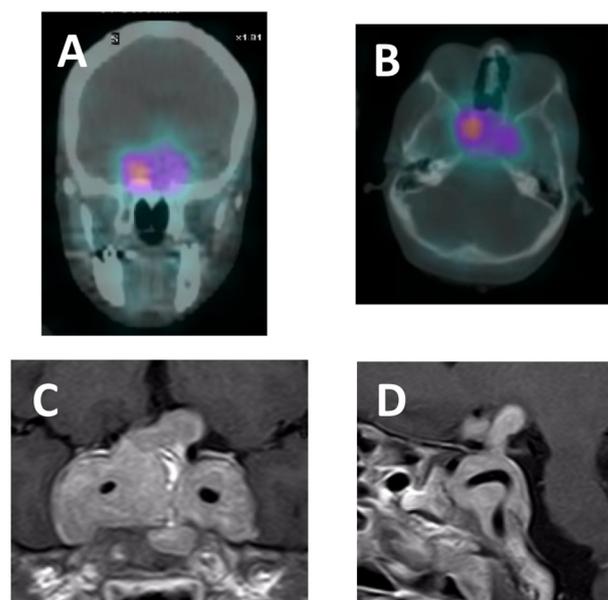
Coronal (A) and axial (B)  $^{111}\text{In}$ -pentetreotide SPECT CT images showing a hypercaptant lesion located in the suprasellar region. T1-weighted coronal (C) and sagittal (D) MRI images showing the presence of an aggressive lactotroph adenoma.
